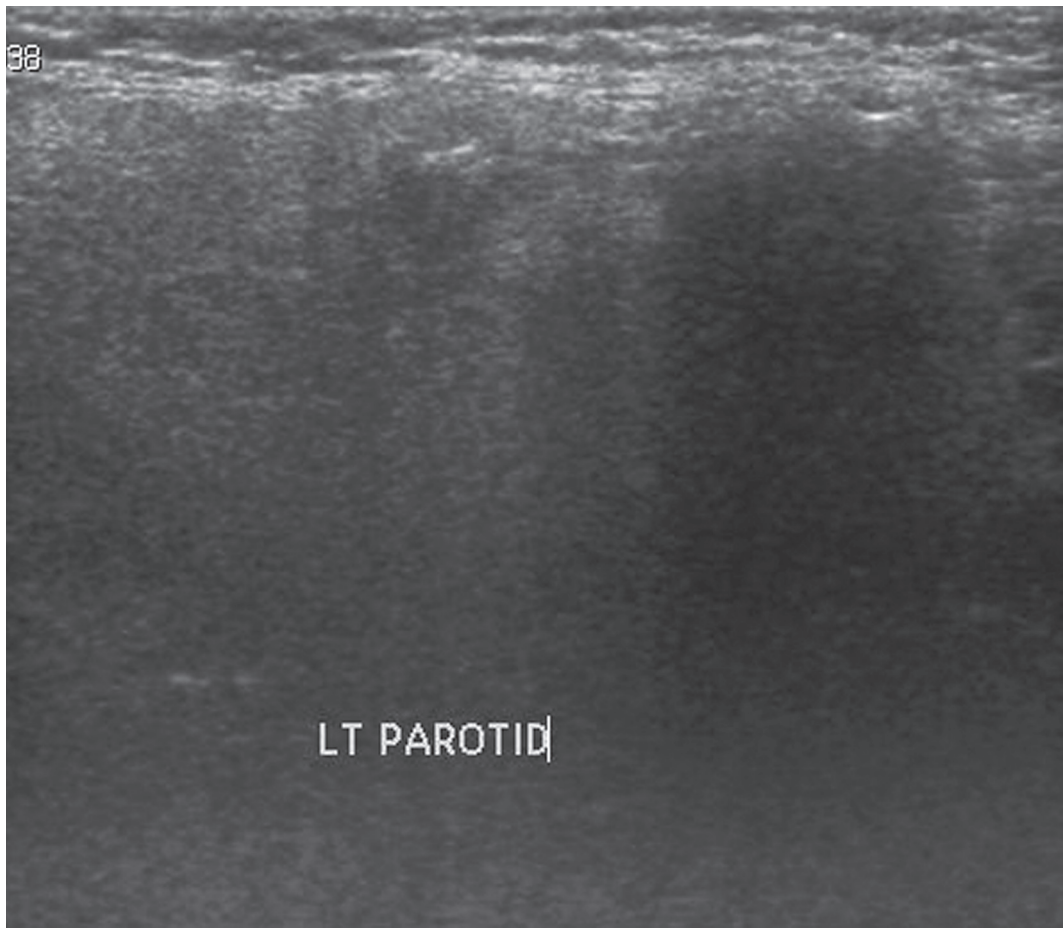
Ultrasound-guided injection of the parotid gland.
